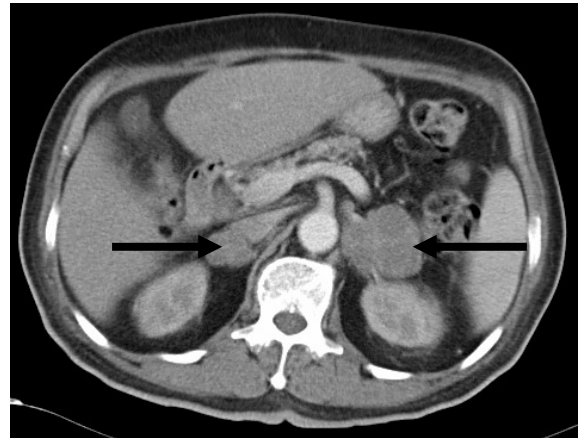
Axial computed tomography scan showed heterogenous enhancing bilateral adrenal enlargement (arrow) measuring 5.0 x 4.0 cm on the left (attenuation value, 30-40 HU) and 4 x 3.6cm on the right (attenuation value, 40-50 HU) with peripheral enhancement and septations.
